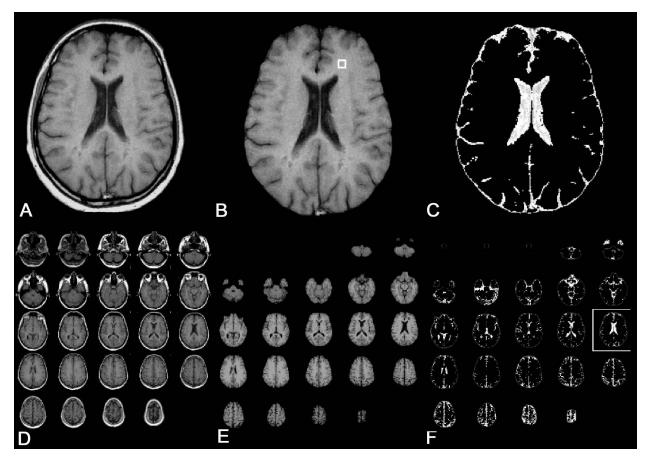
Semiautomated method of determining brain parenchymal fraction, a normalized measure of whole brain atrophy in MS, from the Buffalo Neuroimaging Analysis Center (adapted in part from ref. 37). (a-c): A single axial slice, spin-echo T1-weighted noncontrast, from an MS patient showing the raw image (a), after masking (removal) of extracranial tissue has been performed to isolating the outer brain contour (b), and after thresholding to separate the intracranial volume into brain parenchyma (black pixels) and CSF (white pixels) (c). (d-f): Shows that the same algorithm is applied to all axial images from the mid-cerebellum to the vertex. The image surrounded by the large white square (f) is used to identify normal appearing white matter on which a region-of-interest is placed in the normal appearing white matter (b, small white box) to determine the threshold for parenchyma vs. CSF segmentation (37). The BPF is the ratio of the brain parenchymal volume to the intracranial volume (volume within the surface contour including the subarachnoid space) and is thus a normalized measure. With recent software improvements, the total analysis time per patient is 10 minutes.
